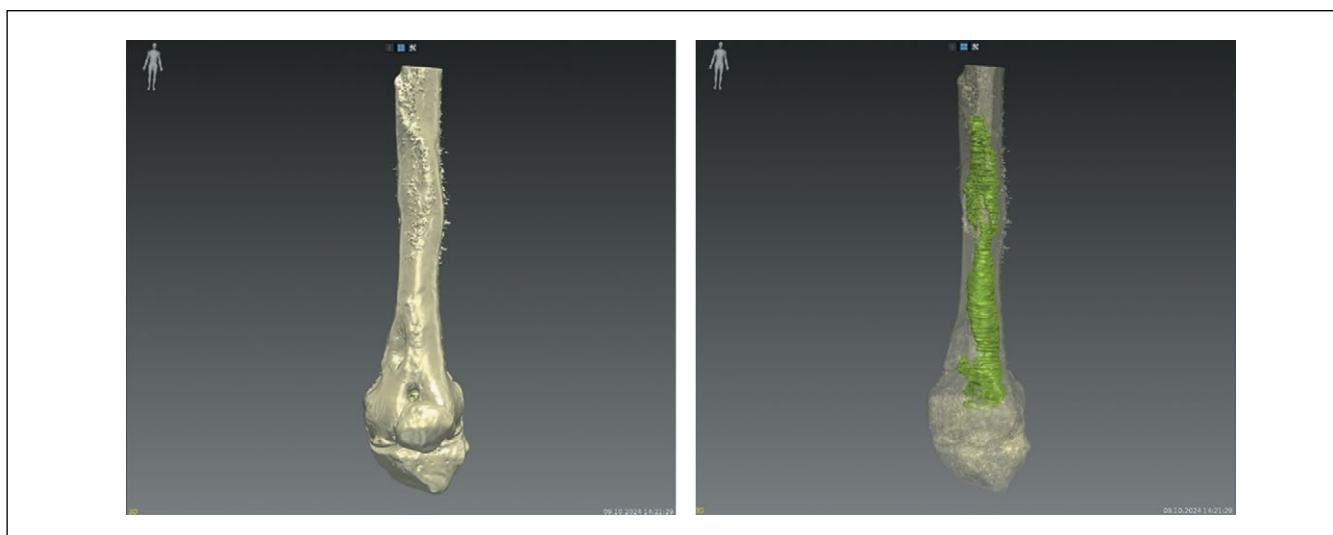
3D model of the femur based on the CT scan. The osteomyelitis lesion is shown in green.
